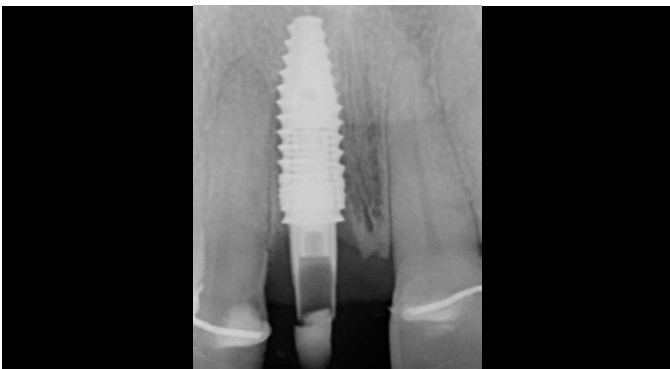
Radiographic view at six-month follow-up confirming osseointegration
